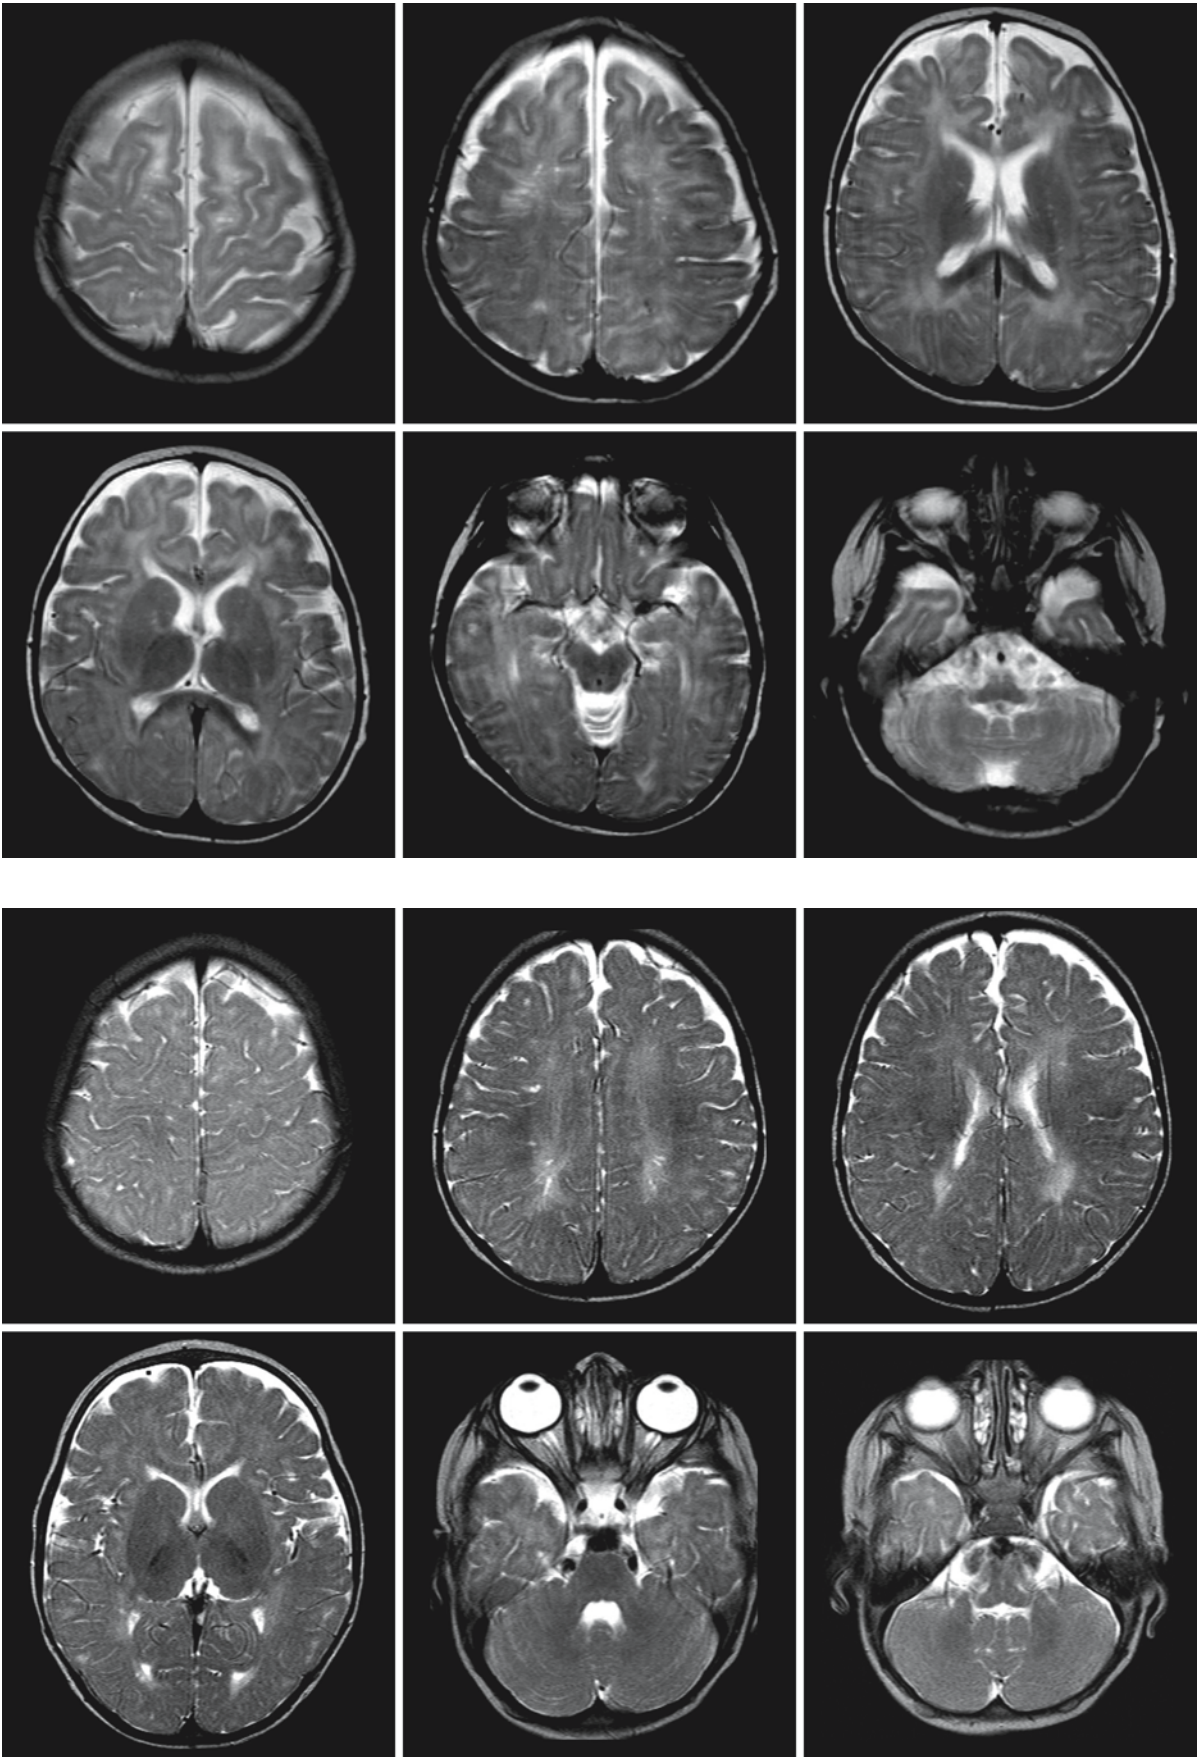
A 1-year-old boy just diagnosed with biotinidase deficiency. He presented with an acute metabolic crisis. The MRI shows delayed myelination and mildly enlarged subarachnoid spaces. There are more prominent signal abnormalities in the deep parietal white matter, where the white matter also looks spongy with many tiny cysts, possibly enlarged perivascular spaces. Courtesy of Dr. Z. Patay, Department of Radiology, and Dr. P.T. Ozand, Department of Pediatrics, King Faisal Specialist Hospital and Research Center, Riyadh, Saudi Arabia
